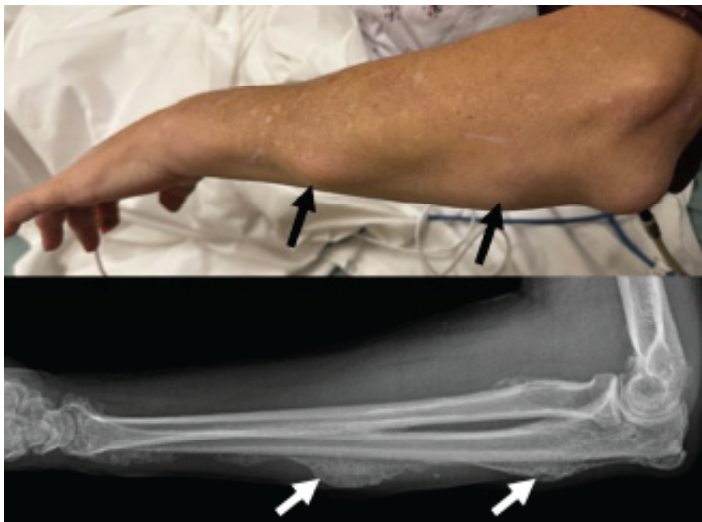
Top: Several non-mobile, hard lesions on the left forearm (black arrows). Bottom: Radiograph revealing periosteal new bone formation throughout the left forearm (white arrows).
